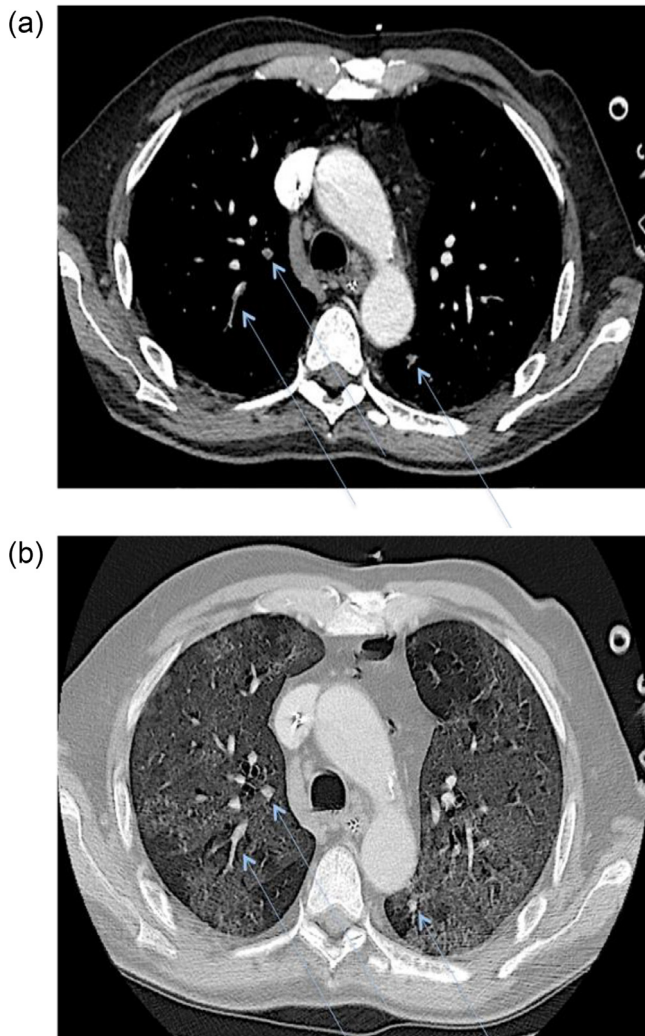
Axial contrast-enhanced CT scan demonstrating simultaneous multiple thrombi with bilateral involvement (A) (blue arrows) affecting subsegmental pulmonary artery branches within extensive ground-glass opacities (B).
